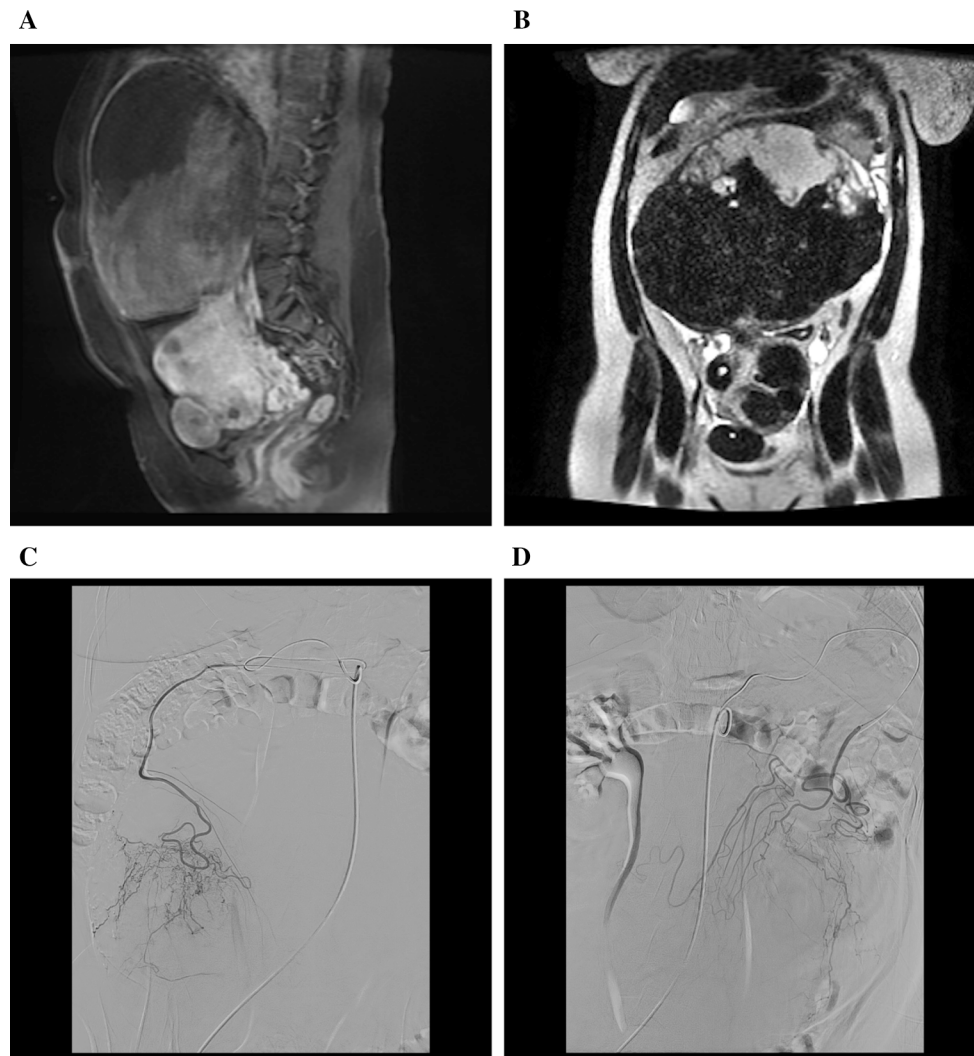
Omental artery supply to the fibroid uterus. A 39-year-old woman (patient 3) undergoing pre-myomectomy workup and embolization. A, B Sagittal lava post-contrast and coronal T2-weighted single-shot fast spin-echo images demonstrate an enlarged
